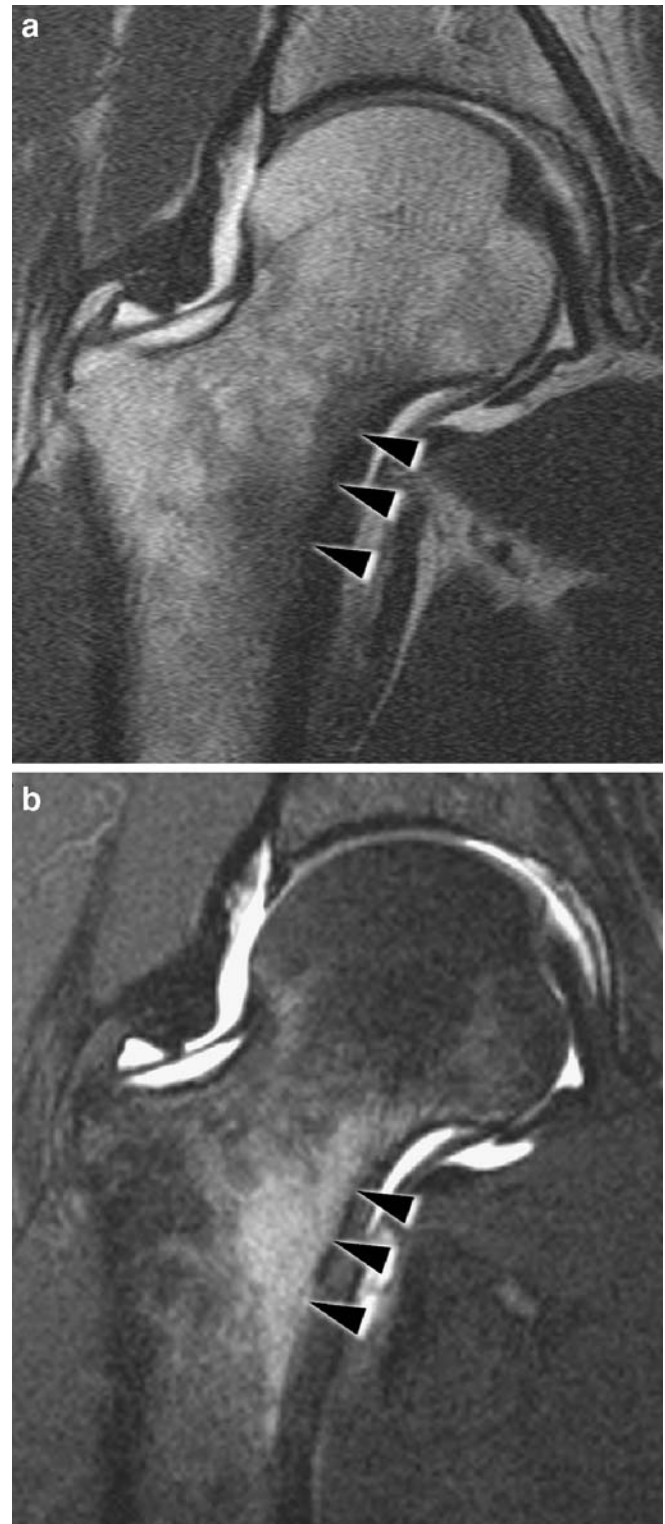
Femoral neck stress reaction. MR arthrogram with a coronal T1-weighted spin echo image and b fat-suppressed T2-weighted turbo spin echo image. The medial femoral neck is the typical location for a stress reaction or fatigue fracture. In this case bone marrow edema-like abnormalities (*black arrowheads*) without a fracture line are visible
